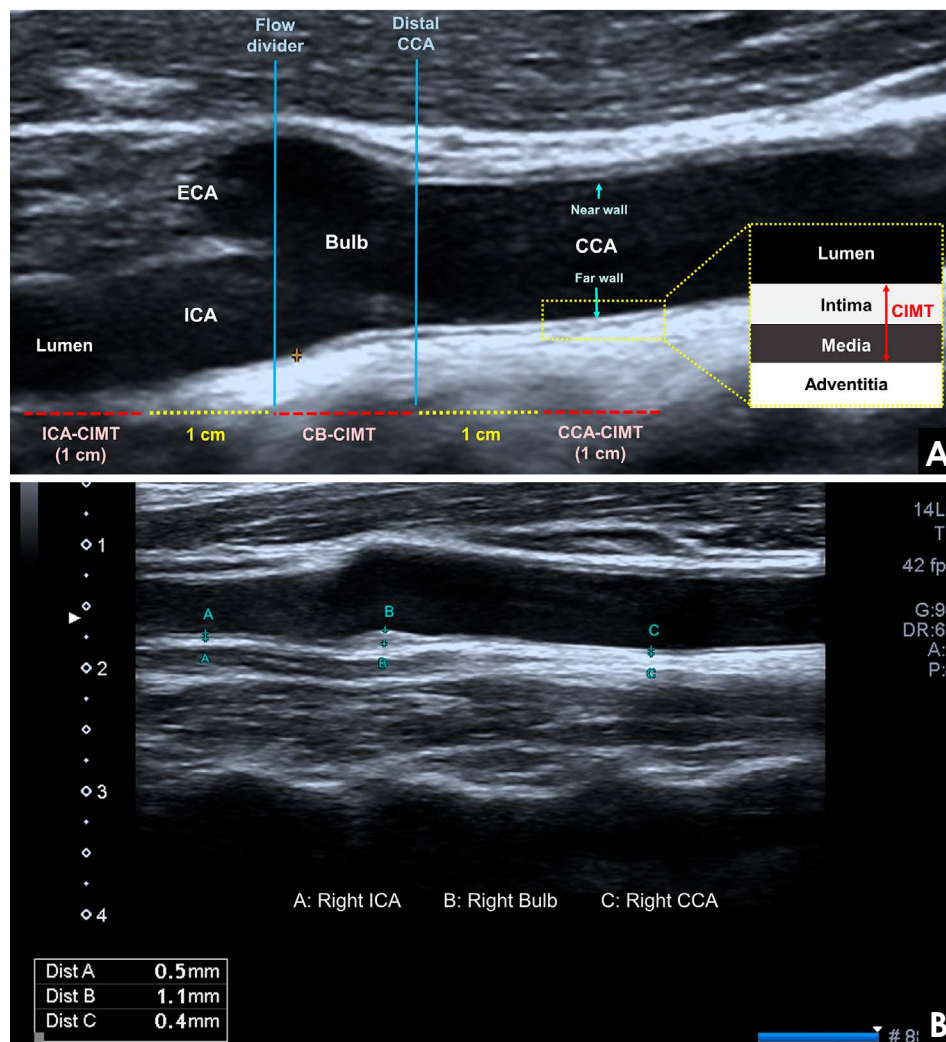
A. Carotid intima-media thickness (CIMT) is defined as the distance between the lumen-intima interface (the upper bright line) and the media-adventitia interface (the lower bright line) on the far wall. The protocols for measuring CIMT were applied bilaterally at 3 locations: the common carotid artery (1 centimeter below the distal common carotid artery), the carotid bifurcation (from the flow divider to the distal common carotid artery), and the internal carotid artery (1 centimeter above the flow divider). B. Sonographic image of CIMT measurement at the 3 levels.
